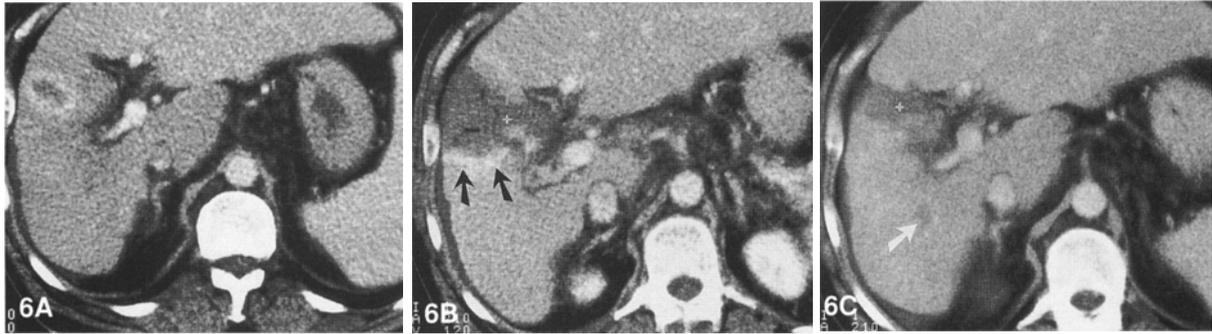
Infiltrating HCC treated with PEI alone: findings on contrast-enhanced spiral CT. A A hypervascular HCC is seen in the left lobe (segment 4) of a cirrhotic liver. The lesion is poorly defined against the surrounding parenchyma. B One day after PEI, a large hypoattenuating area is seen in segment 4, indicating necrosis. The enhancing area (arrows) corresponded to residual viable tumor on fine-needle aspiration biopsy and additional treatment was needed. C Six months later, the area of necrosis has decreased in size, indicating local tumor control. However, a small secondary lesion has appeared in the right lobe (arrow).
